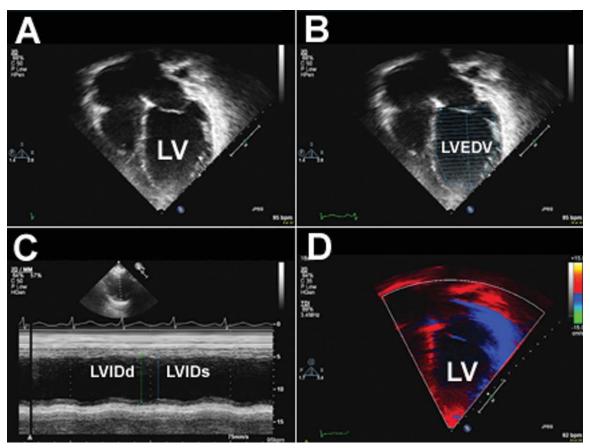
Echocardiographic images of a 16-year-old DMD patient with cardiomyopathy. (A) Two-dimensional apical four-chamber view of a dilated left ventricle (LV) showing thin and rounded lateral myocardial wall and septum. (B) Measurement of the left ventricle end-diastolic volume (LVEDV) in the apical four-chamber view used to calculate ejection fraction. The ejection fraction in this patient was severely decreased at 20% (normal 55-65%). (C) M-mode image of the left ventricle showing decreased movement of the interventricular septum at the top of the image and the lateral free wall at the bottom of the image. The left ventricular internal diameter in diastole (LVIDd: green line) and the left ventricular internal diameter in systole (LVIDs: blue line) are measured to derive the shortening fraction (LVIDd - LVIDs / LVIDd). This image shows a severely decreased shortening fraction of 9% (normal 28-40%). (D) Color tissue Doppler image of the left ventricle (LV). The coloring of the ventricular myocardium corresponds to myocardial velocities that are measured to evaluate diastolic function and myocardial strain. [Color figure can be viewed in the online issue, which is available at wileyonlinelibrary.com.]
